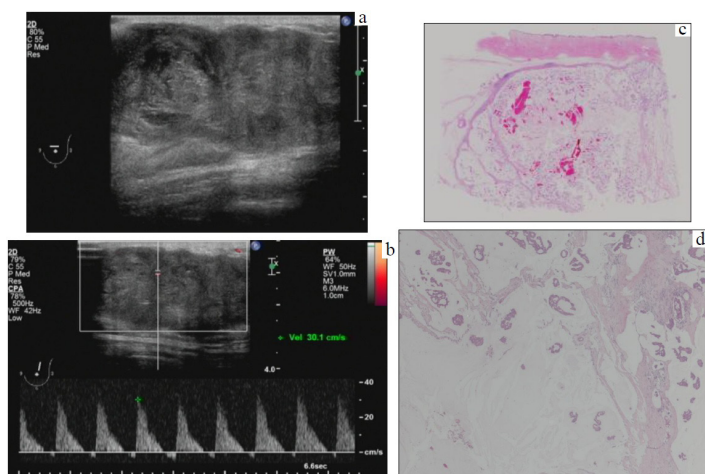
Ultrasonic pulsed Doppler finding of phyllodes tumor by preoperative ultrasonic diagnostic examination.
